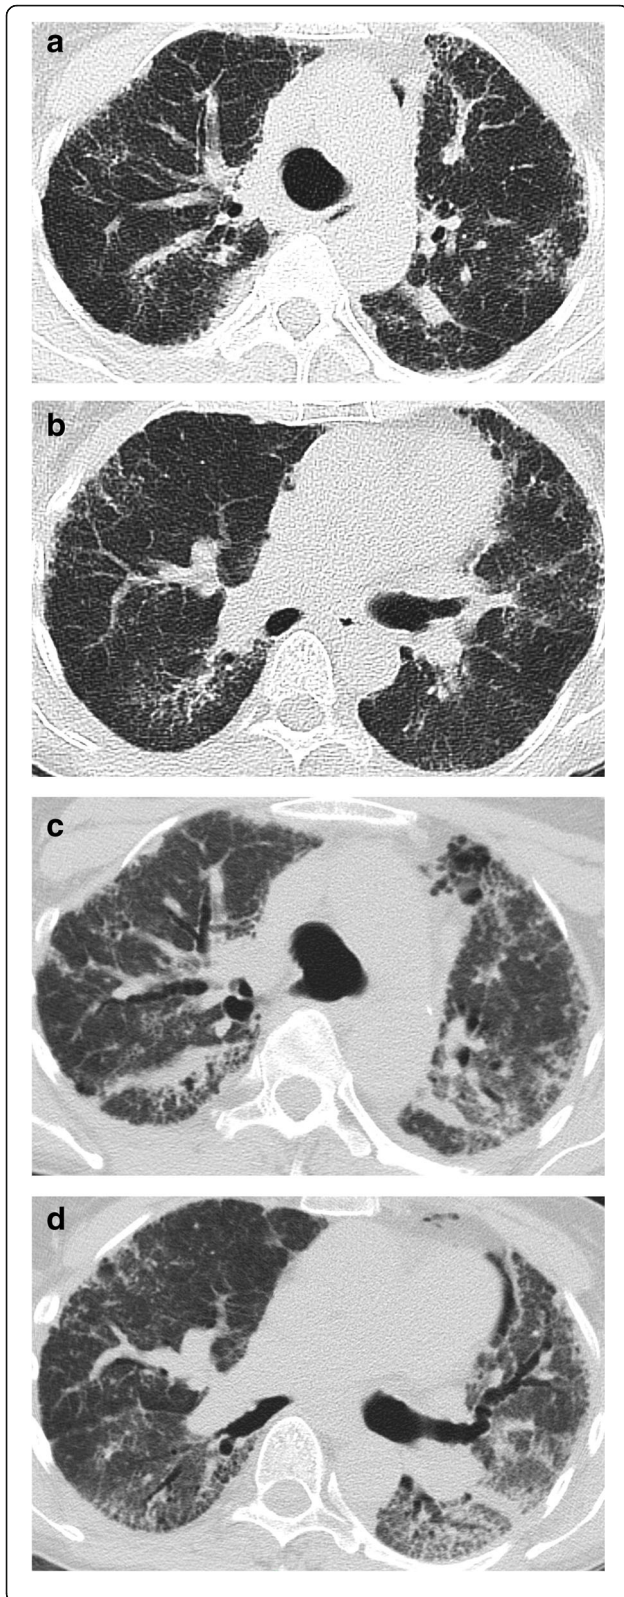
High-resolution computed tomography (axial plane) of the chest showing worsening of lung fibrosis with thickening of peribronchovascular interstitium, bronchiectasis, reticulations, honeycombing, ground glass opacities and lung parenchyma consolidations. Initial examination (a, b) and three-month follow-up (c, d)
